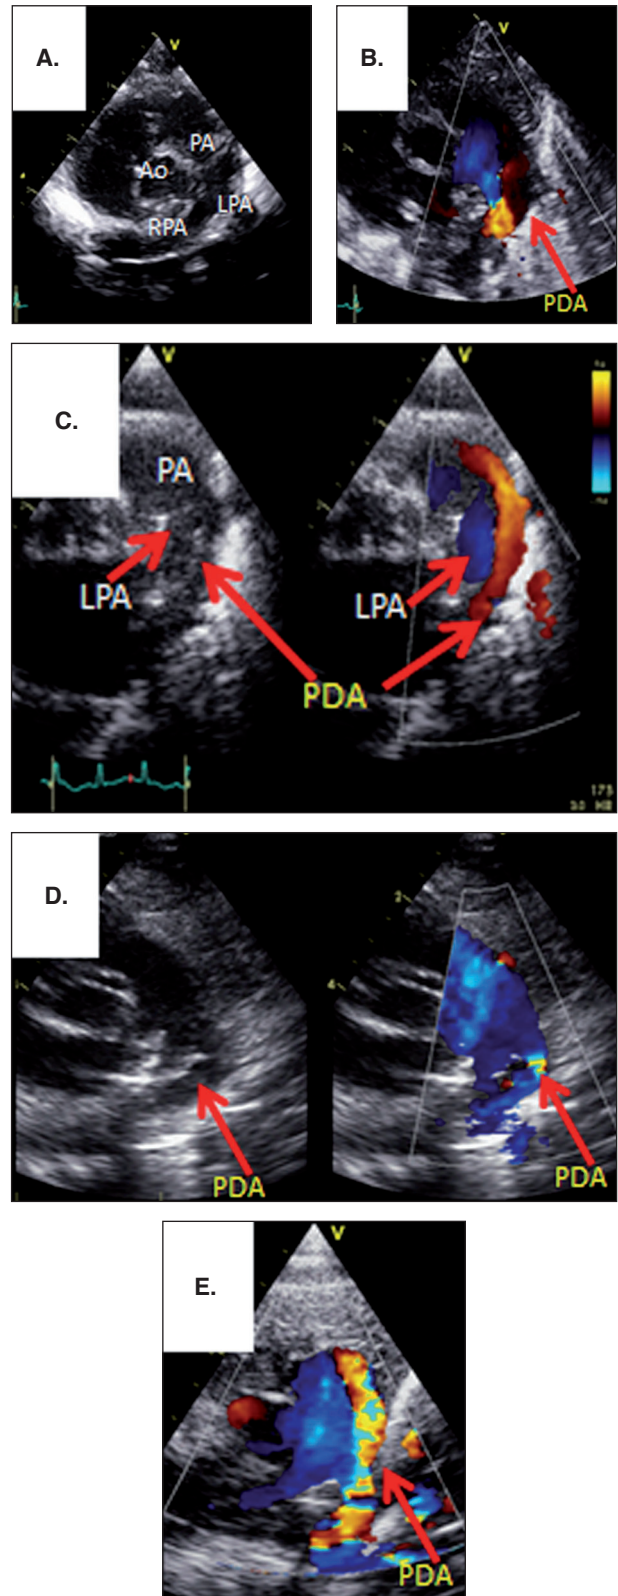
A. Short axis parasternal view at the level of heart base, with normal anatomy. B. Large PDA pattern (wide red jet extends for short distance in the PA). C. Moderate PDA pattern (narrow red jet deeply extends inside the PA). D. Pulmonary hypertension pattern with blue color flow. E. Restrictive PDA pattern with mosaic color jet deeply extends inside PA.
